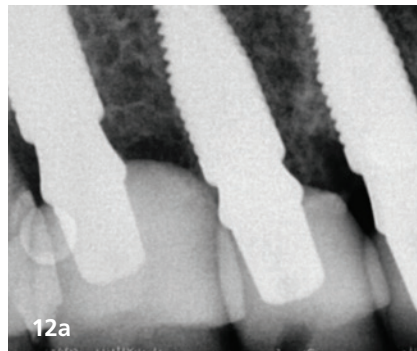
Definitive crowns in lithium disilicate. Fig. 10b: Definitive crown in monolithic zirconia. Figs. 11a & b: Clinical appearance after 12 months of follow-up. Figs. 12a & b: 12-month follow-up periapical radiograph.
